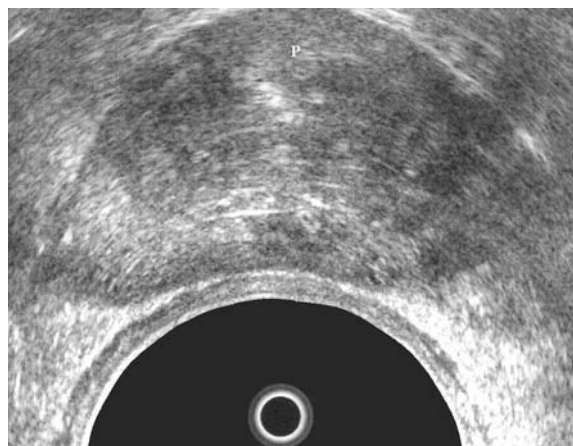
36. Sonographic view of the prostate (*P*)
